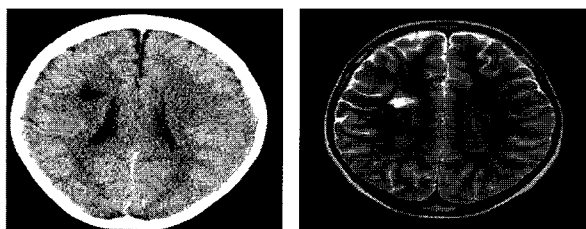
CT shows a low density area in the right frontal lobe. Fig. 2. T2-weighted magnetic resonance imaging reveals triangular shaped high signal intensity lesion in right frontal white matter.
